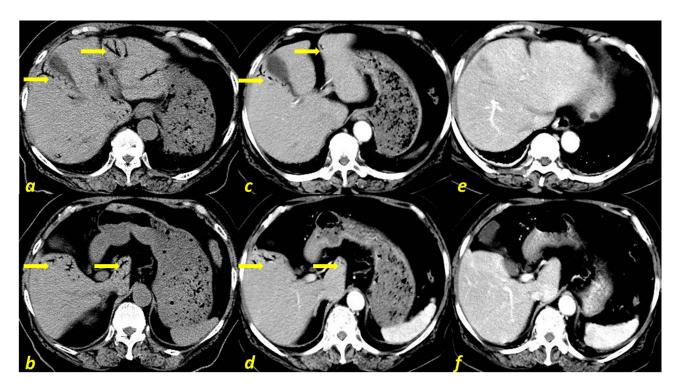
Figure I (a and b) The first CT scan indicated that the gas was located at the liver edge (yellow arrow) more like HPVG. (c and d) Contrast-enhanced abdominal CT showed a significant reduction of gas. Compared with the yellow arrows in (a and b) the gas shadows in (c and d) are significantly reduced. (e and f) In contrast to the yellow arrows in (a and b), contrast-enhanced abdominal CT showed disappearance of intrahepatic biliary tract gas.
